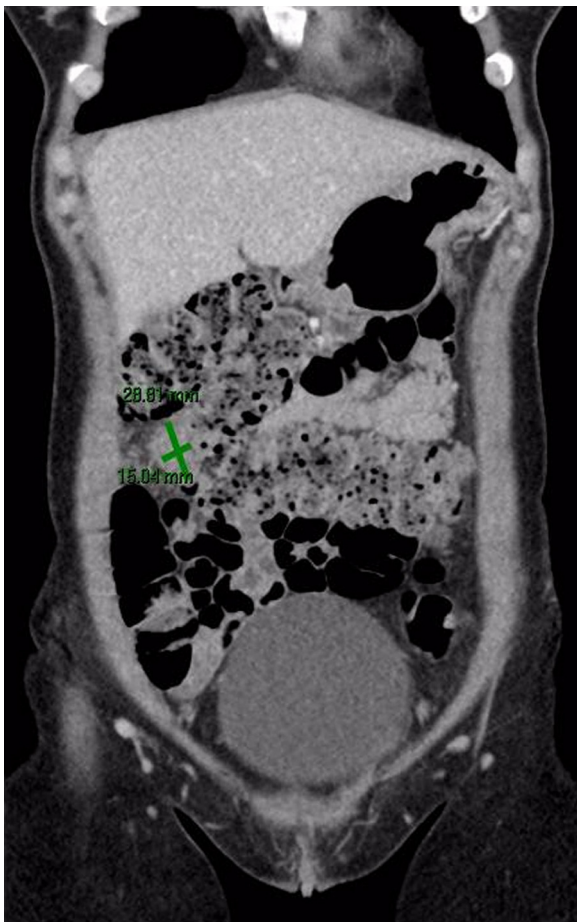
(Greyscale and colour). Contrast enhancement coronal computed tomography showing showing ovoid mass in proximity to transverse colon.
